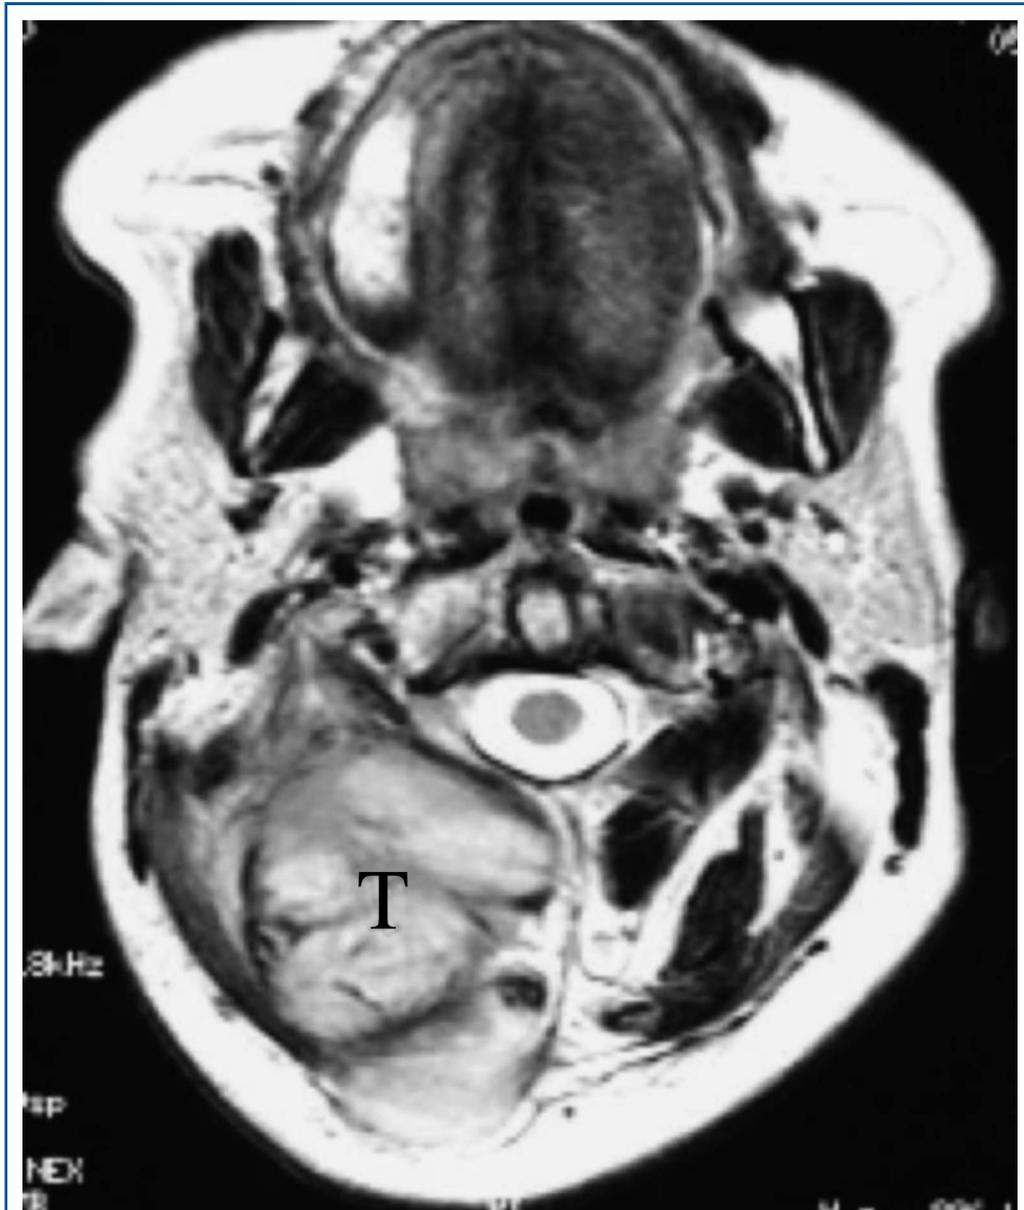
Extensive subcutaneous tumour recurrence (T) in the neck of a patient eight months after primary surgery for a cerebellar glioblastoma (axial T2 MR image).
